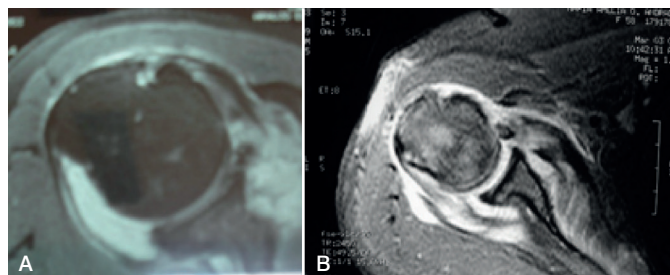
A and B. Magnetic resonance imaging of the shoulder (axial section) showing, in both cases, subscapular tear and dislocation of the long head of biceps
